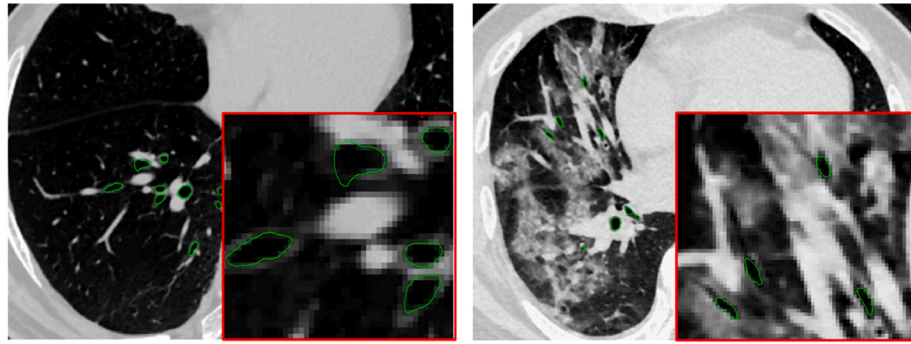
Comparison of the CT image of the lung of COVID-19 patients (right) with healthy people (left) including the airway identification.
